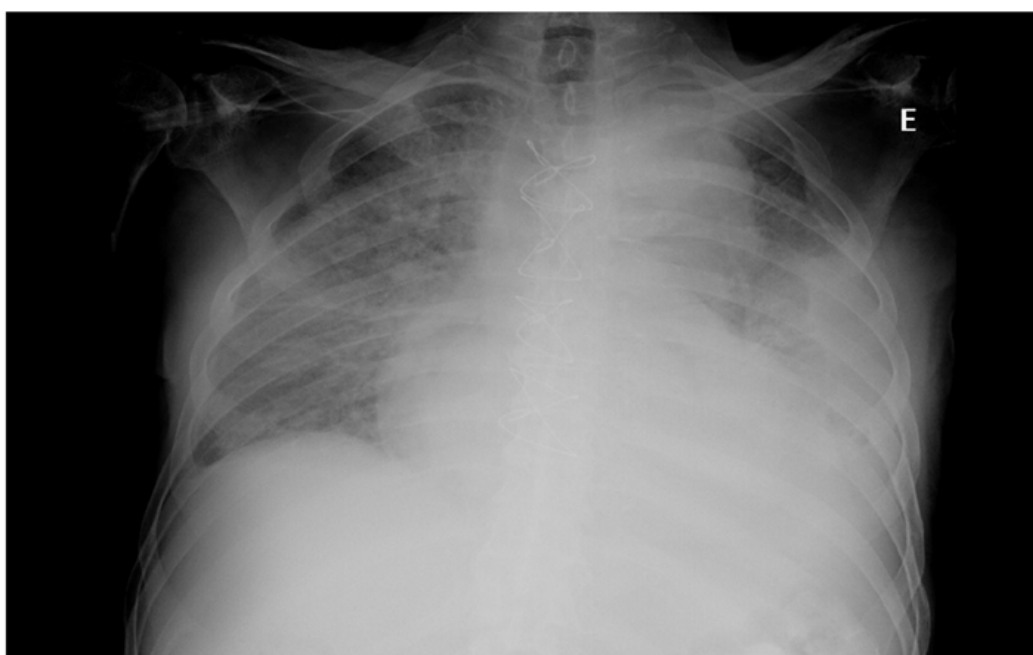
Chest radiography showing evidence of left-sided pleural effusion.
